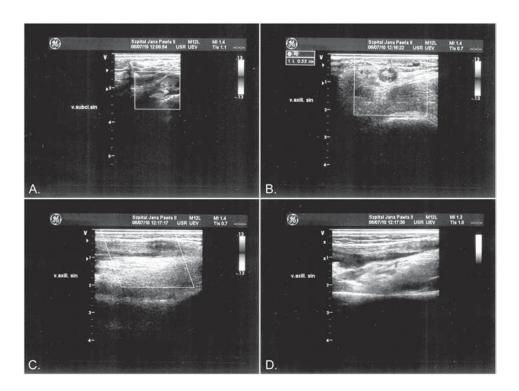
Venous ultrasound examination. A. Left subclavian vein with the pacemaker lead. Note old recanalised thrombi visible in the distal part of the vein, with turbulent flow and partially patent vessel lumen (50% stenosis); B. Left axillary vein dilated to 0.55 cm in diameter and obstructed with a large thrombus, with blood flow limited to a narrow lateral stream (90% stenosis); C, D. A thrombus extends to the distal part of a brachial vein, up to the point where brachial veins join, where it occludes only 30% of the vessel lumen
